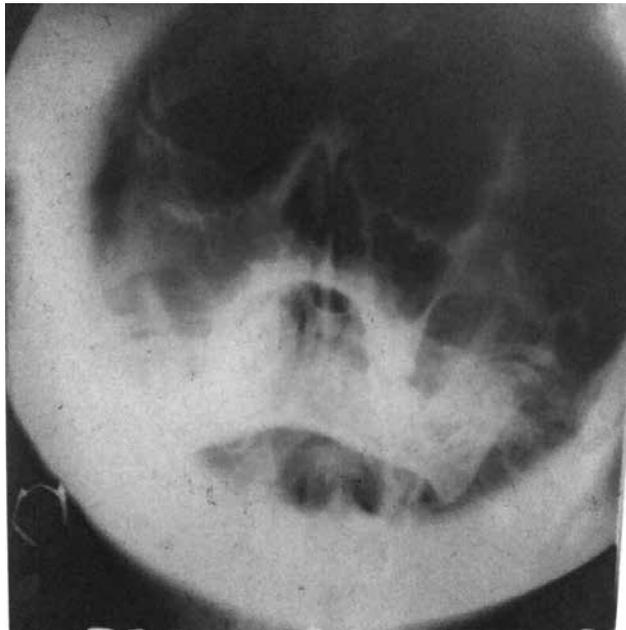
X-ray image showing opacity of the right maxillary sinus.
